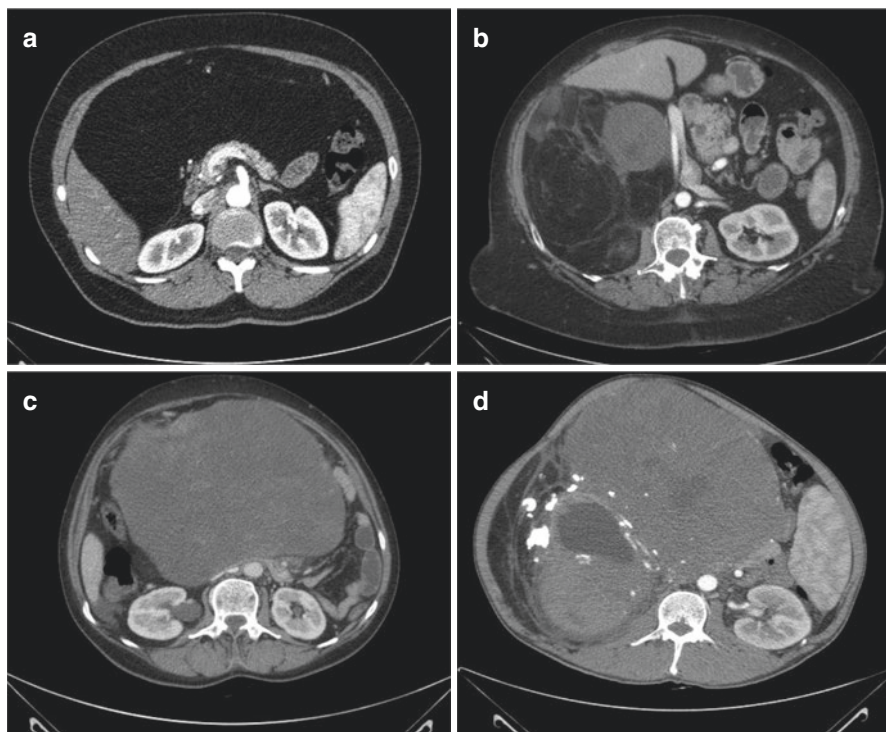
(a) Well-differentiated liposarcoma in its entirety, without areas of dedifferentiation. Radiologically, it can be difficult to differentiate by CT a well-differentiated liposarcoma from a lipoma. (b) Liposarcoma with lipomatous aspect (well-differentiated component) and dense solid area (differentiated component). The operation should be a “*en bloc*” resection, taking care not to consider the well-differentiated area as part of the retroperitoneal fatty tissue. (c) Dedifferentiated liposarcoma without lipogenic sarcomatous tissue, sometimes difficult to distinguish from undifferentiated pleomorphic sarcomas. (d) Dedifferentiated liposarcoma with an epithelioid/pleomorphic pattern and areas of calcification
